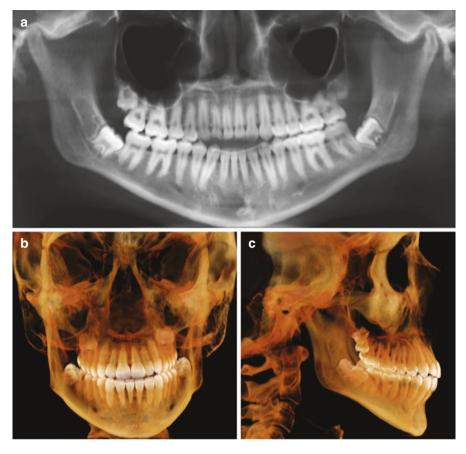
CBCT reformats show elongation of the right condyle without vertical lengthening of the ramus (c), right Class III molar relationship (a), and deviation of the mandibular midline to the left (b), suggestive of hemimandibular elongation
